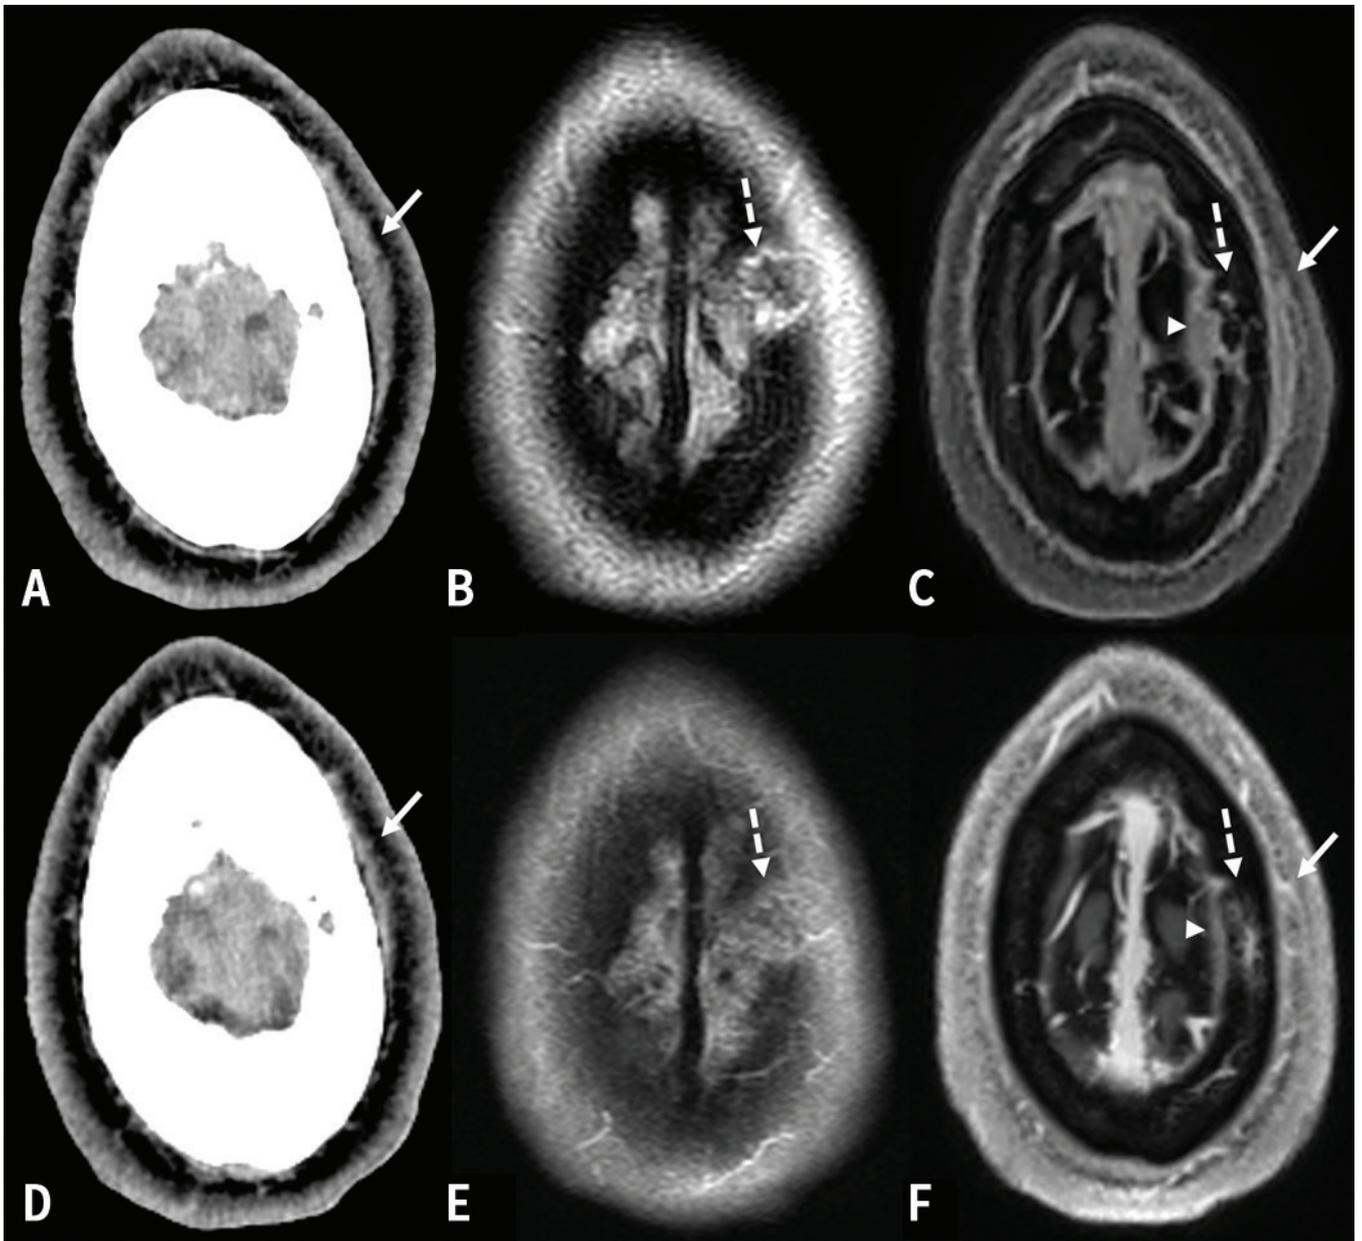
Soft tissue and marrow changes in a 25-year-old patient with syphilitic osteomyelitis. (A) Axial initial computed tomography (CT) and (C) contrast-enhanced, fat-saturated T_1 -weighted magnetic resonance images (MRIs) show soft tissue swelling overlying the left parietal osseous lesion (arrow). The CT performed 2 weeks after initiating treatment shows improvement (D), and the contrast-enhanced T_1 -weighted MRIs obtained about 10 weeks (F) after treatment was initiated show resolution (solid arrows). (C, F) Underlying dural thickening also shows marked improvement (arrowheads). Evolution of marrow edema and enhancement (dashed arrows) corresponding to the osseous lesion seen on CT is visible in (B, E) axial fluid attenuated inversion recovery (FLAIR) images and (C, F) contrast-enhanced images of MRI performed initially and 10 weeks after treatment initiation, respectively.
